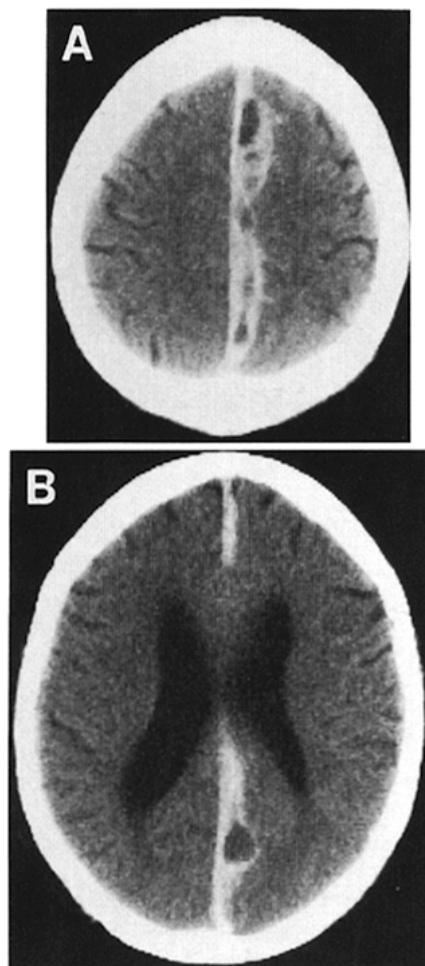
A* and *B*, CT without contrast at admission disclosing a left-sided ISH with compartments of various densities and "pseudomembranes" compatible with a recent hemorrhage in a more chronic ISH.
